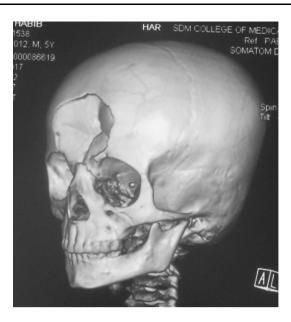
Three-dimensional reconstruction of computed tomography reveals the depressed fracture of the frontal bone
